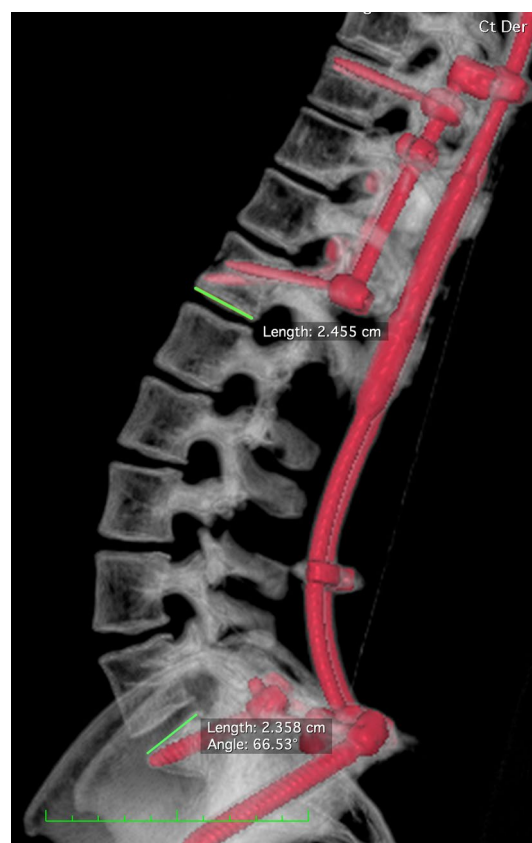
3D reconstruction from a CT scan at the end of the distraction phase. In comparison with the preop images, the disc spaces have been reduced in volume, the segmental lordotic angles have reduced and the posterior annuli have been stretched. The slow shortening of the spine over time not only permitted further angular correction but also a significant translation of the lordosis apex backwards towards the instrumentation
